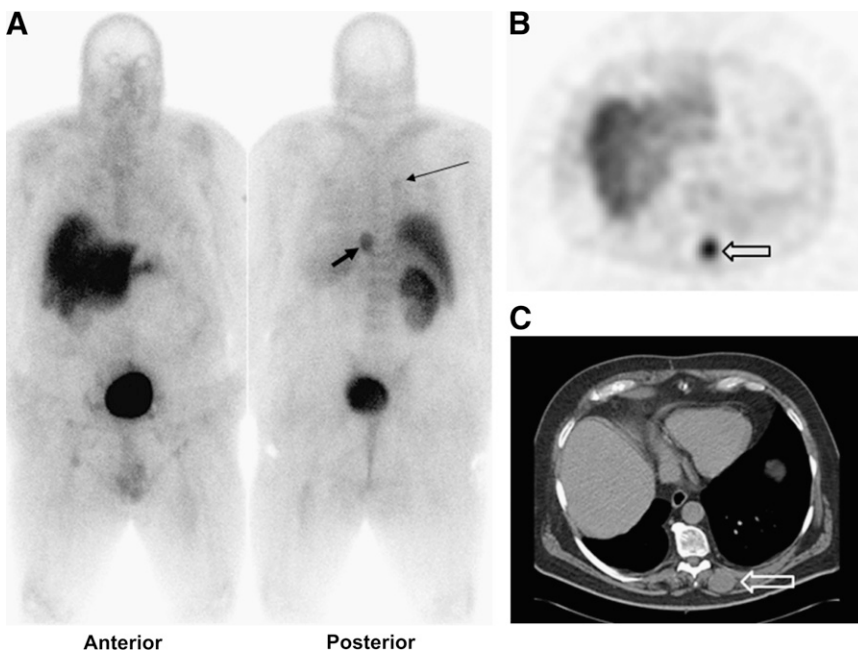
^{99m}Tc -EC20 images of 57-year-old man with known pulmonary metastases from renal cell carcinoma. Anterior and posterior whole-body planar images (A) revealed faint uptake of tracer in right upper-lobe pulmonary nodule (1.8 × 2.1 cm) (thin arrow) that was demonstrated on CT (not shown). More intense tracer uptake was seen in mass (2.7 × 3.5 cm) (thick arrow) in left paraspinal muscles. Planar images also revealed faint bilateral inguinal nodal uptake of ^{99m}Tc -EC20. Paraspinal mass also was demonstrated on transverse SPECT image (B) and corresponding CT image (C) (arrows).
